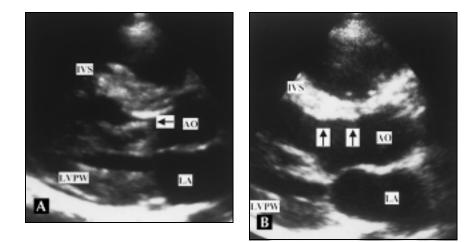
Parasternal long axis view at systole before (*panel A*) and 1 year after (*panel B*) percutaneous septal ablation (PTSMA). *Panel A* shows complete systolic anterior movement-septal contact (*arrow*) at the friction area of the septum (IVS). One year after PTSMA thinning of the subaortic septum (IVS) and left ventricular posterior wall (LVPW) are observed. AO—aorta; LA—left atrium.
